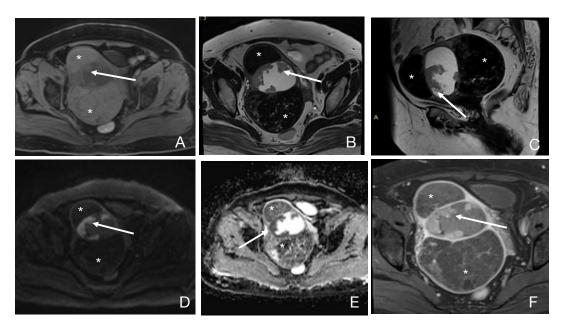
(A to F): T1w axial (A), T2w axial (B) and T2w sagittal (C) MRI pelvis images further reveal well defined lobulated and encapsulated lesion seen in the perineum appearing intermediate intensity on T1w and heterogeneously hyperintense on T2w (white arrows) which shows restricted diffusion (D and E) and marked contrast enhancement (F). Anterolaterally, the lesion is involving the vaginal vault on the left side, posteriorly abutting the rectum, anal canal and external sphincter on the left side without any obvious invasion and inferiorly reaching up to the skin surface without any skin ulceration.
